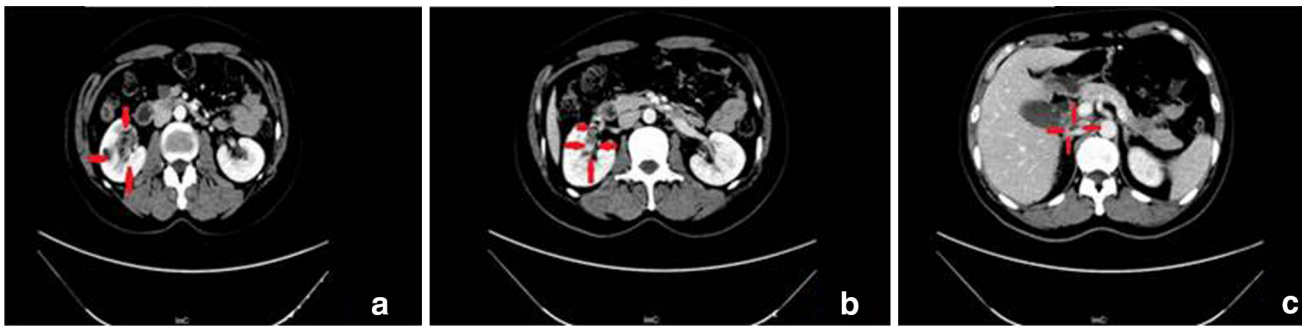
Contrast-enhanced computed tomography images. a, b The mass was heterogeneously hyperenhanced in the corticomedullary phase and iso-enhanced in the late phase. b, c A filling defect was detected in the RRV (b) and IVC (c), revealing a tumor thrombus in the vein
